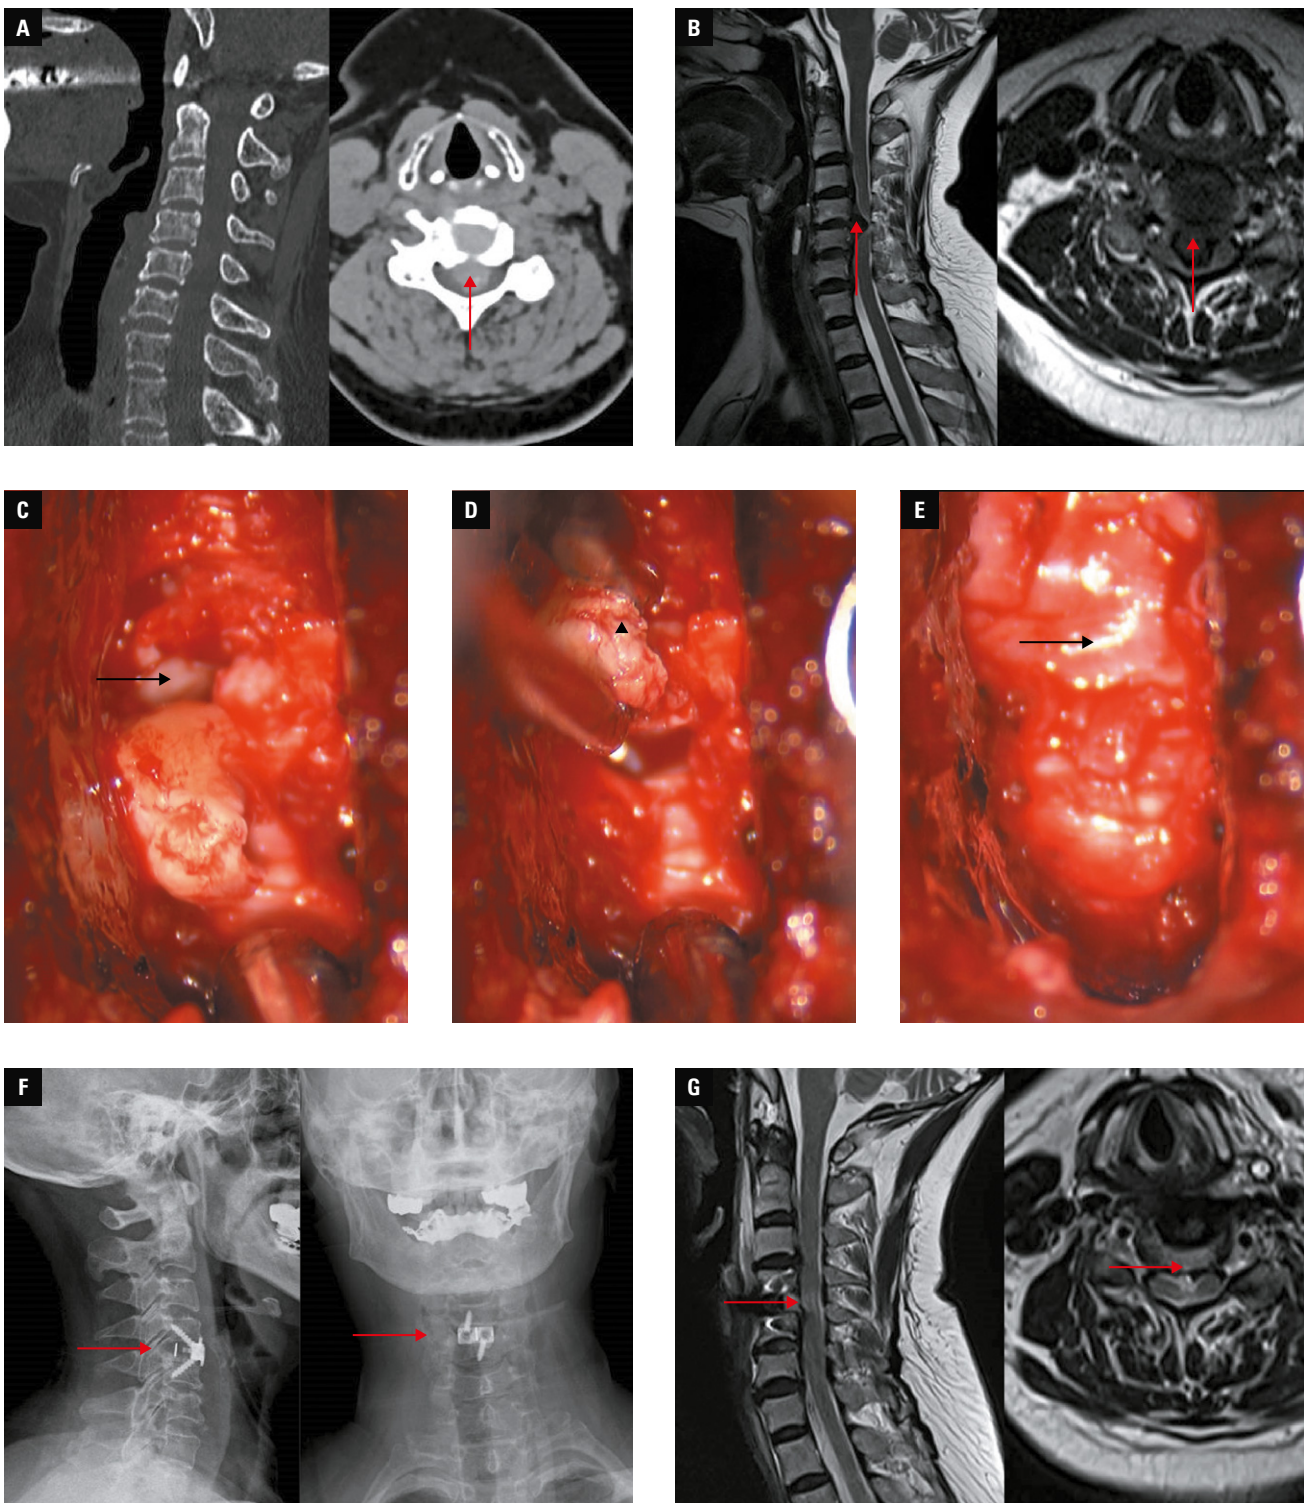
Case 1. A 37-year-old woman with weakness and numbness in the lower extremities lasting for 6 months; A – preoperative sagittal computed tomography showing no ossification of the posterior longitudinal ligament, and a coronal view showing giant disc herniation in the C4/C5 intervertebral space (arrow); B – preoperative magnetic resonance imaging (MRI) showing giant disc herniation in the C4/C5 intervertebral space, compressing the spinal cord (arrows); C – herniated giant cervical disc compressing the spinal cord and forming a depression (arrow); D – removal of the herniated cervical disc (arrow); postoperative MRI showing the herniated giant disc completely removed, and the spinal cord adequately decompressed (arrow); E – spinal cord swelling and filling up after the herniated cervical disc removal to relieve the compression; F – postoperative frontal and lateral radiographs showing the implanted zero-profile system (arrows); G – postoperative MRI showing the herniated giant disc completely removed and the spinal cord adequately decompressed (arrows)
